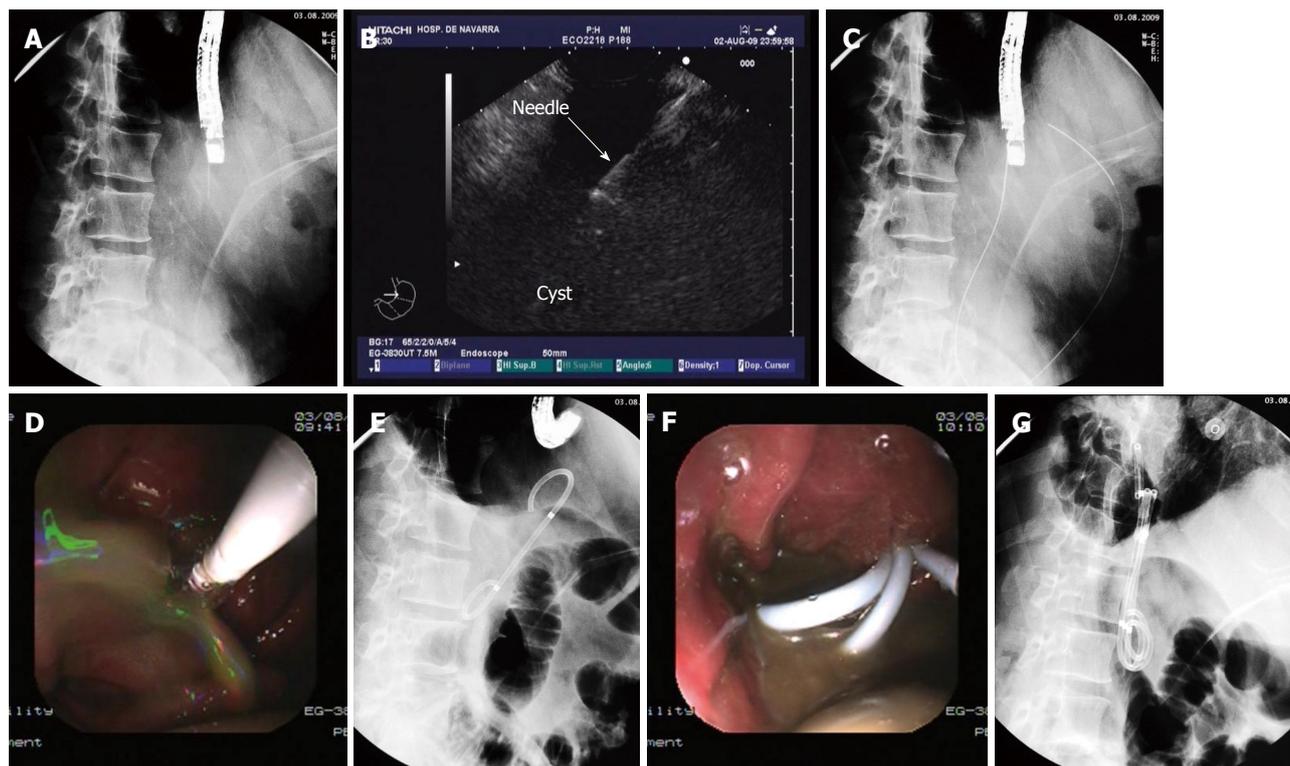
Approach to drain the pseudocyst. A: In this fluoroscopic image the linear array echoendoscope is inside the gastric lumen in a stable and straightened position, with the needle coming out of the working channel; B: EUS image with linear array echoendoscope in which the needle can be seen inside the cyst once the puncture has been made; C: The guidewire is inserted through the needle and curled inside the cyst cavity; D: With deflation of the balloon dilator the pseudocyst contents spurts through the fistula into the gastric lumen; E: Fluoroscopic view of the first double pigtail stent inserted through the fistula connecting the gastric lumen and the cyst cavity (Dimensions of the stent: 5 cm long and 10 F diameter); F: Three double pigtail stents can be seen draining the cyst contents into the gastric lumen; G: The three double pigtail stents are placed transmurally. The gastric and cyst lumen can easily be seen on the X-ray image.
